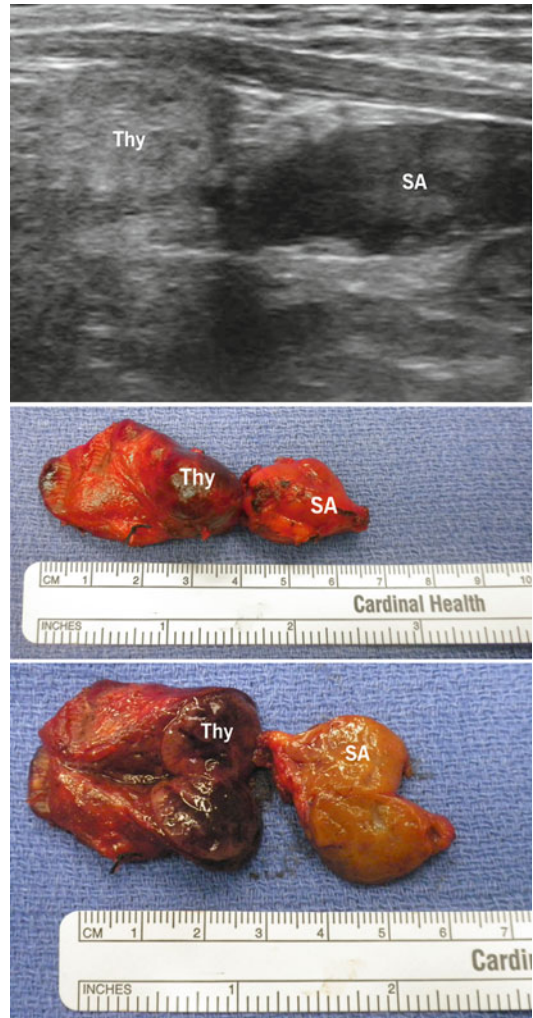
Example of concomitant thyroid pathology in the form of a hyperplastic nodule (Thy) requiring thyroid lobectomy at the time of excision of large single parathyroid adenoma (SA). Both were evident on thyroid ultrasound
